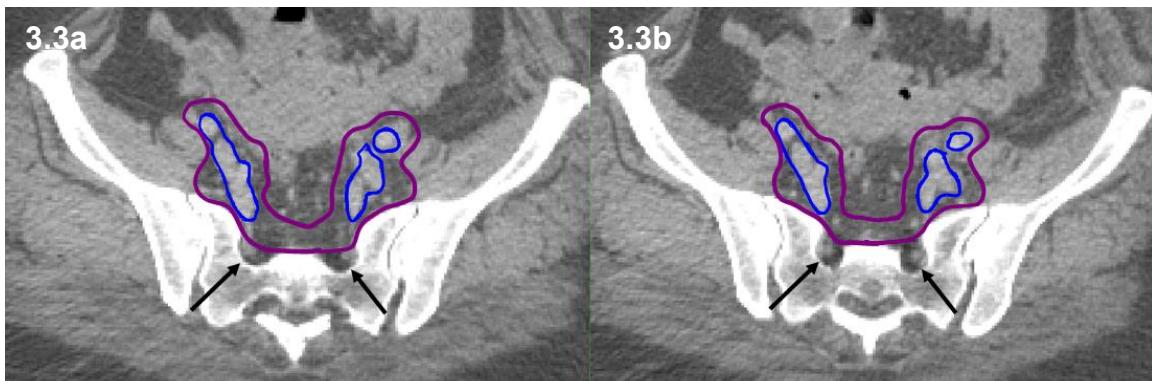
Axial CT of CTV2, not including the sacral foramina (arrowed)
